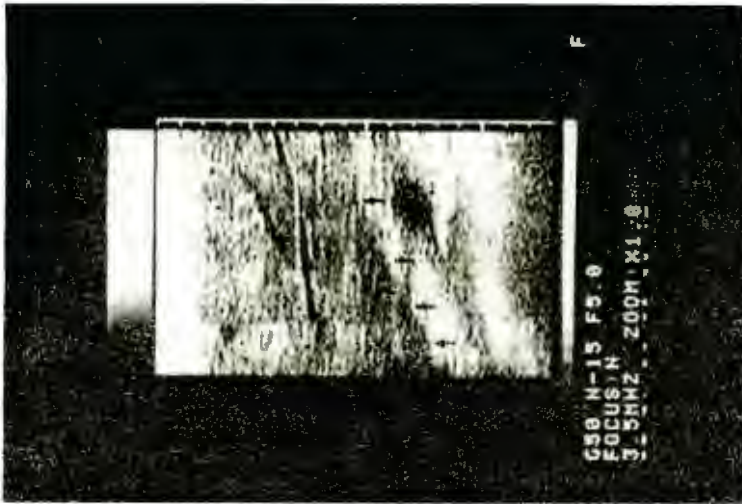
Ultrasongram of a normal liver. PV: portal vein (with echogenic walls); HV: hepatic vein (without echogenic walls); black arrows show hepatic edge.
